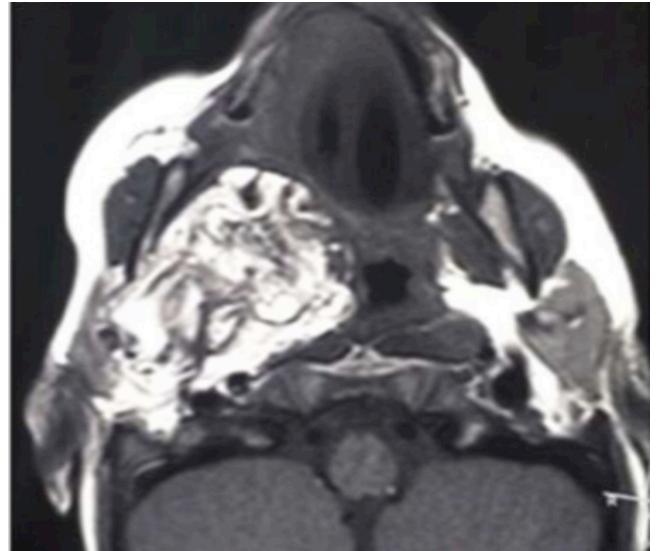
facial T1-weighted MRI axial section showing a high intensity mass of the right infratemporal fossa and the parapharyngeal space
